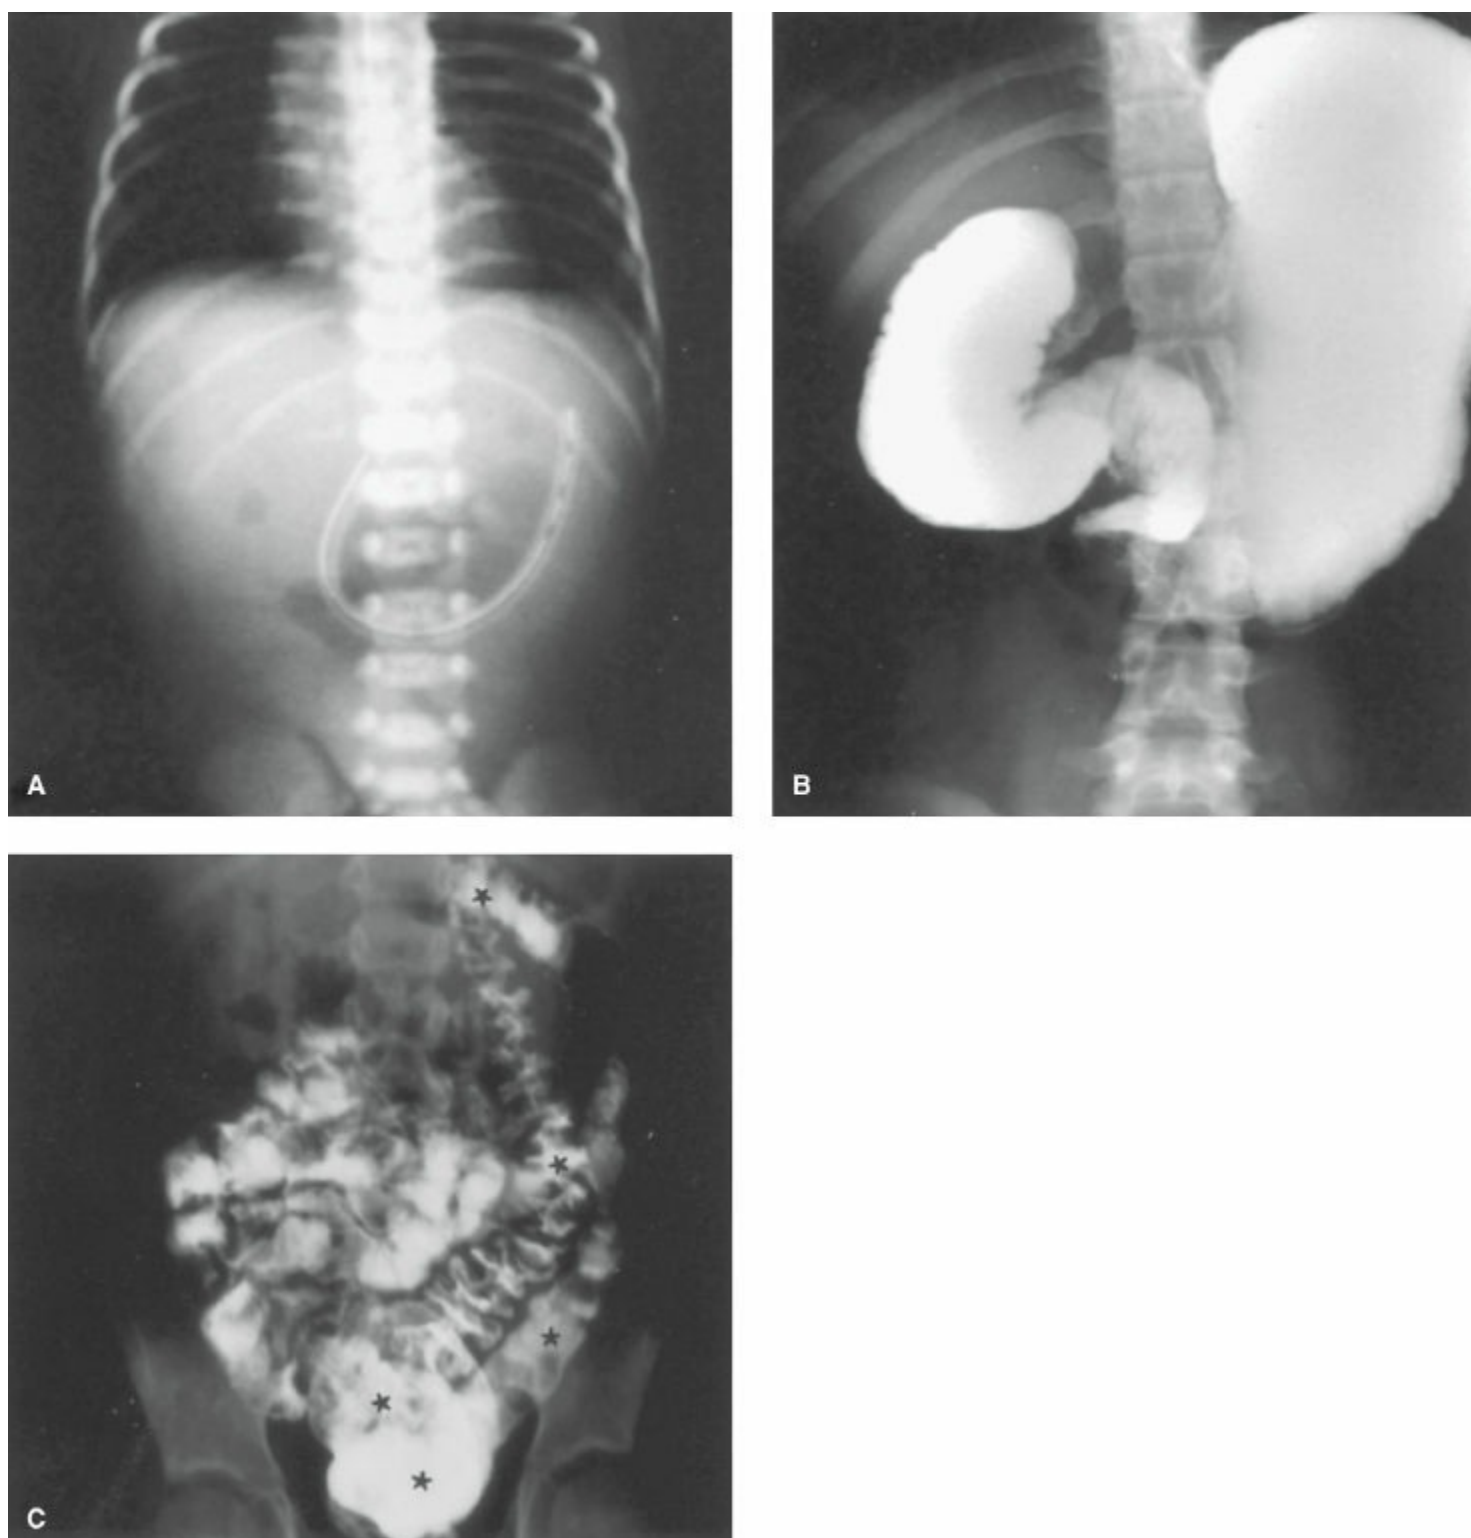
A: Plain radiograph of an infant with malrotation. There is a paucity of small bowel gas. B: Upper gastrointestinal contrast study demonstrating malrotation with midgut volvulus and duodenal obstruction. The position of the duodenojejunal junction is abnormal. C: Plain film showing a contrast-filled colon and cecum on the patient's left (*asterisks*). The entire small bowel is to the right of midline. These are typical radiographic findings of malrotation.
